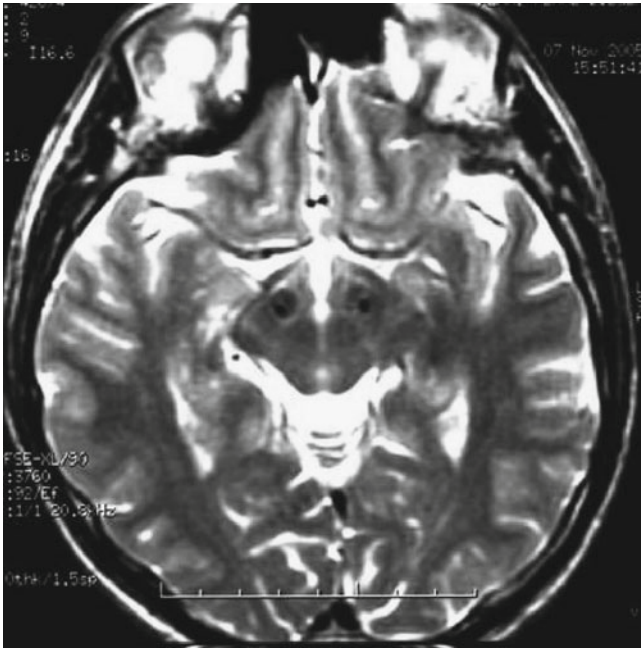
Postoperative axial T2-weighted image of the patient, showing the electrodes in the subthalamic nucleus
